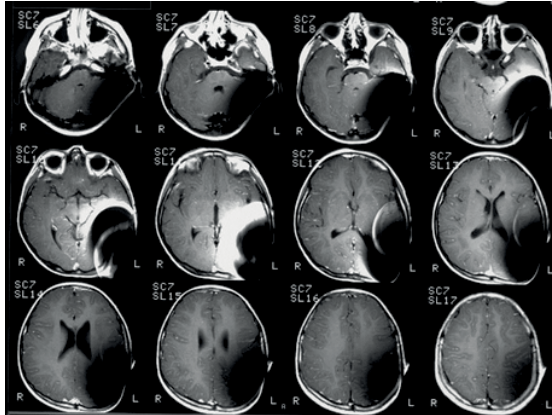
MR images obtained with a 1.5 T scanner (8 year old child)
